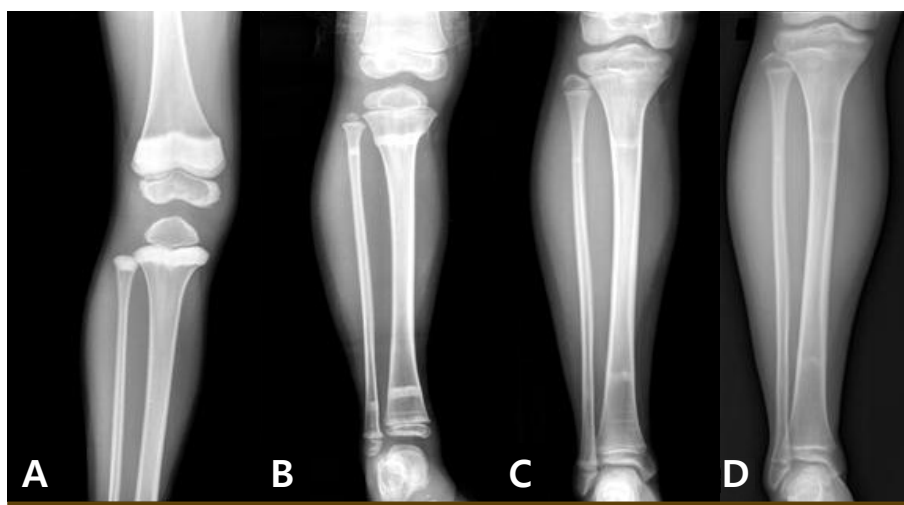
Radiographs of the tibiae were taken in a patient with pamidronate therapy for 14 months. (A) after 5 months, (B) after 1 year, (C) after 8 years, and (D) after 10 years of treating with oral pamidronate. They shows the sclerotic band moves away from physis to diaphysis. And the band tend to disappear in the course of time.
